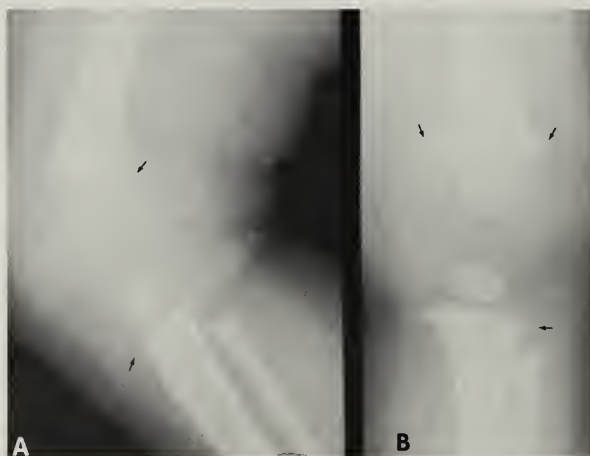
This 7-month female had a swollen knee following an alleged single episode of minor trauma. Radiographs of right knee (A) lateral and (B) anteroposterior showed multiple metaphyseal fragmentations (arrows). Subsequently, a skeletal survey revealed similar findings in the other extremities as well as an occult skull fracture. A diagnosis of child abuse was made.
